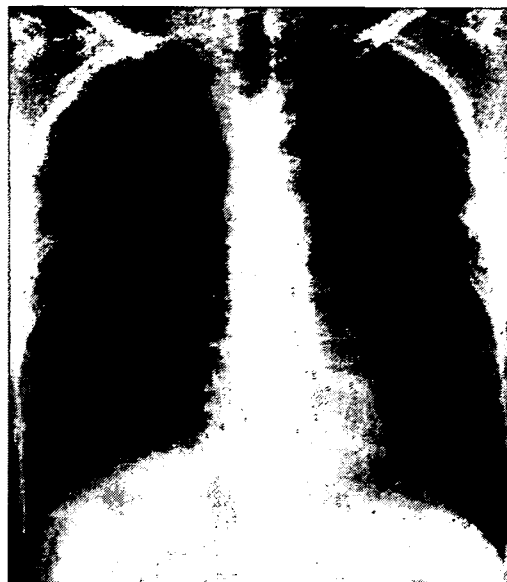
A chest roentgenogram shows an extreme reduction of bilateral infiltrates on the 12th hospital day.
